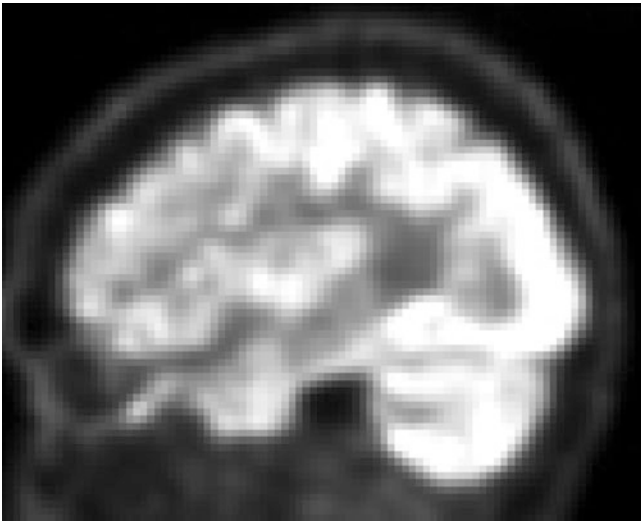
Frontotemporal dementia-sagittal PET. Subtle but definite reduced metabolism in the frontal and anterior temporal lobes 1 year before the MRI show changes. (Reproduced with kind permission from Dr. Lisa Tarlinton and courtesy of Nepean Hospital)
